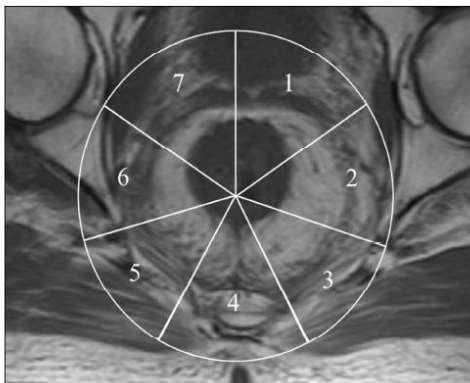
Axial section of mesorectum on MRI showing zones used for defining location of errors within the pelvis.
